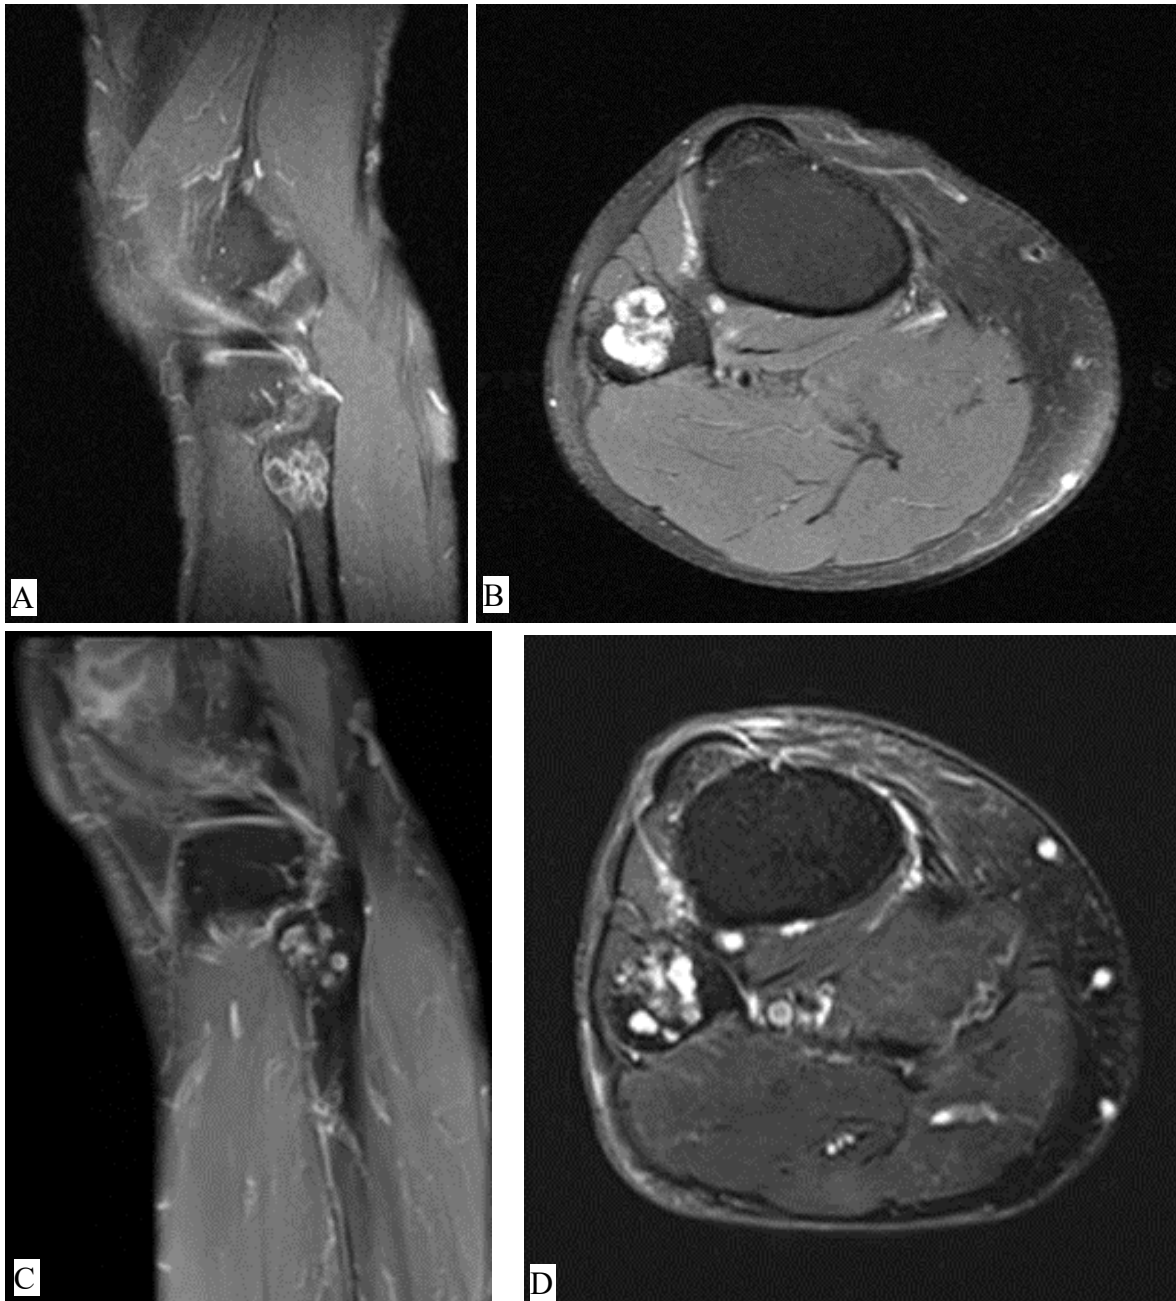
MRI of an EC in the proximal fibula at initial diagnosis (A), (B) with homogenous growth pattern and at the last follow-up (C), (D) with heterogeneous growth pattern and (Department of Radiology, Medical University of Graz)
